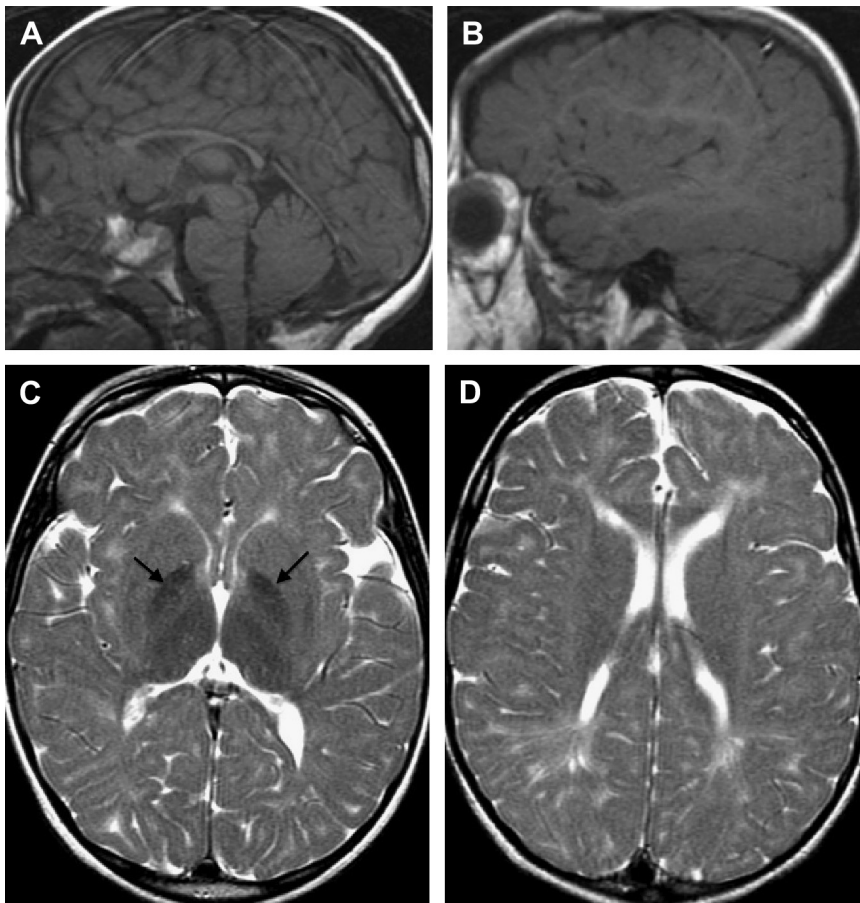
Five-year-old boy with developmental delay/regression, subsequently diagnosed with fucosidosis. Sagittal T1-weighted images (A, B) demonstrate a thin corpus callosum and grossly normal myelination on T1-weighted imaging. Axial T2-weighted images (C, D) demonstrate hypointensity of the globus pallidus (arrows) for age with global decrease in myelination. Some of the periventricular white matter has increased T2 signal greater than hypomyelination, suggestive of gliosis. Cerebellar volume is intact.
